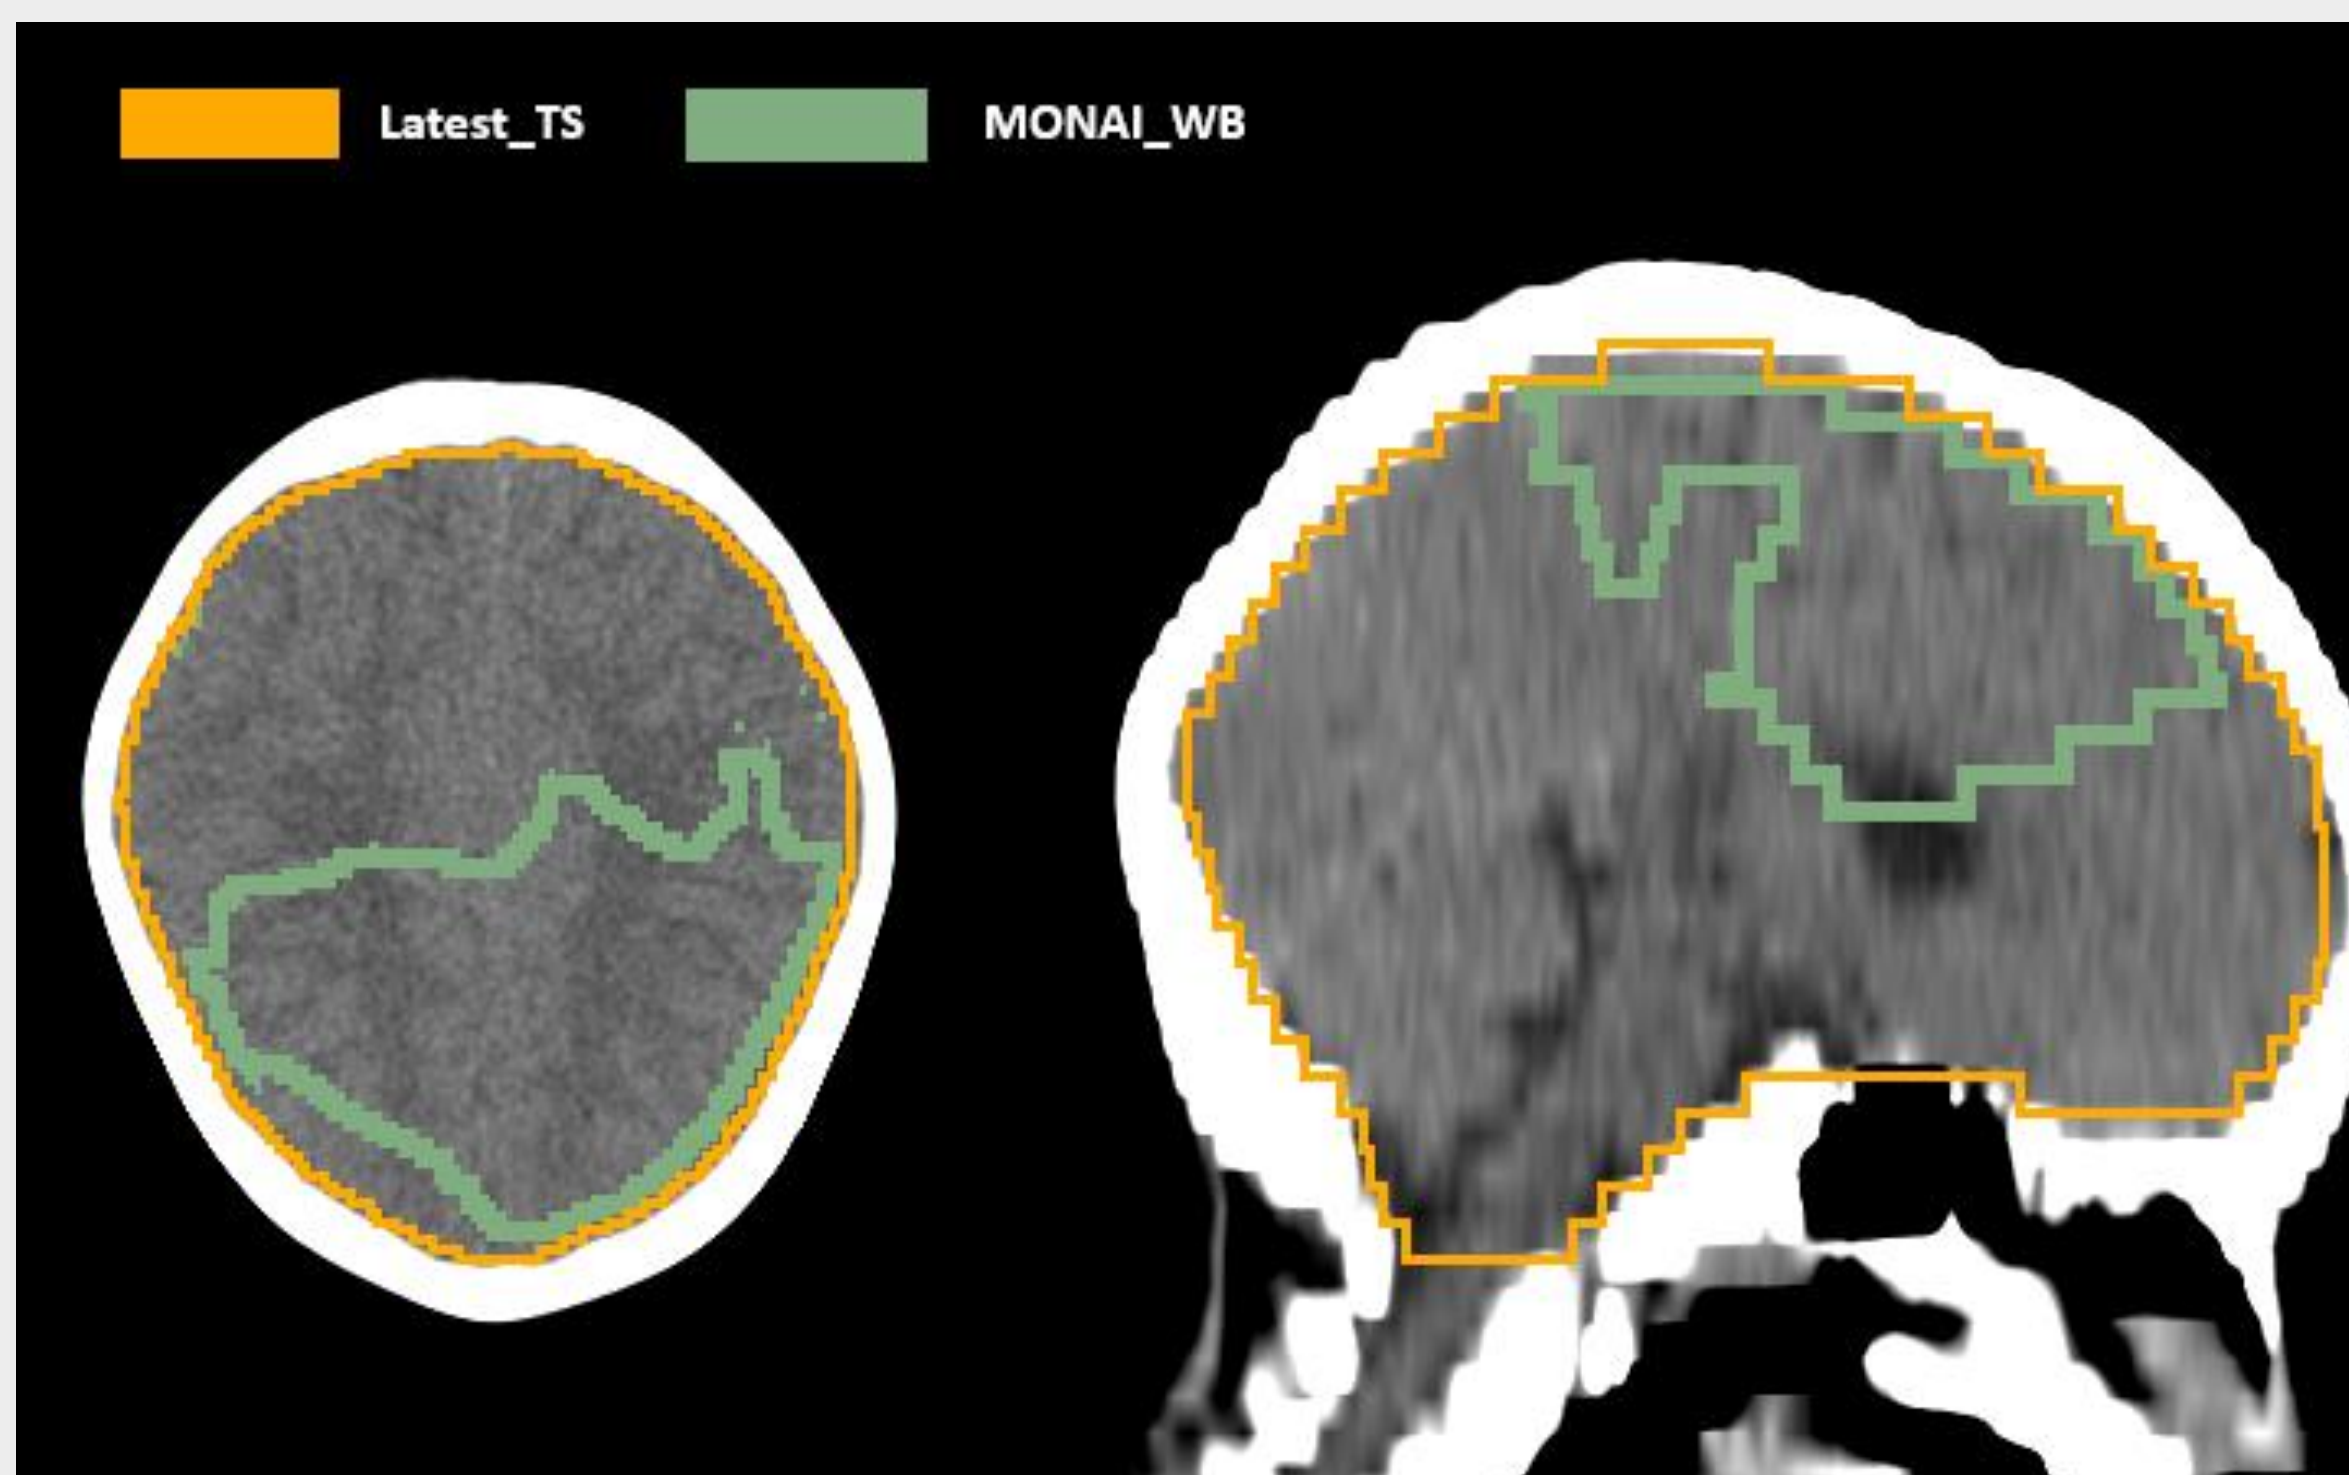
Head CT of a 6-yr-old patient showing brain mis-segmentation by the MONAI_WB model, compared to accurate segmentation by the Latest_TS model
